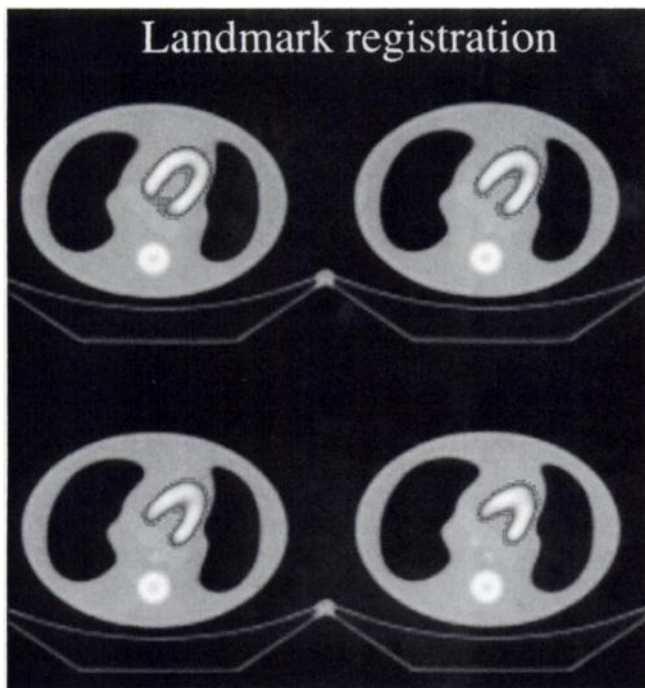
Transverse slices of landmark-registered SPECT images overlaid on CT images.
